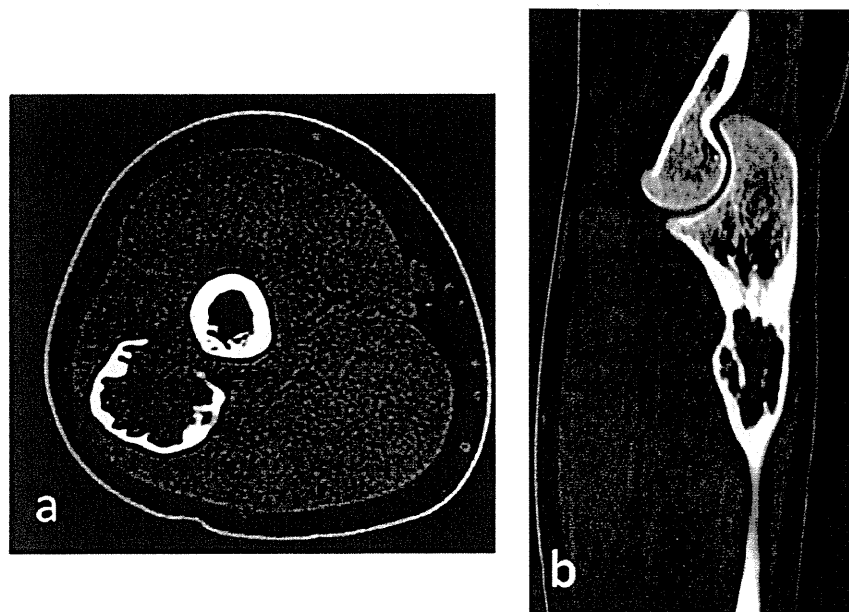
Axial computed tomography scan (a) and sagittal reconstruction (b) of the ulna, demonstrating destruction of the cortex of the ulna, with extension into the adjacent soft tissue. At the edge of the destructed cortex overhanging a soft tissue mass (arrows), which had invaded into the cortex (arrowhead).
